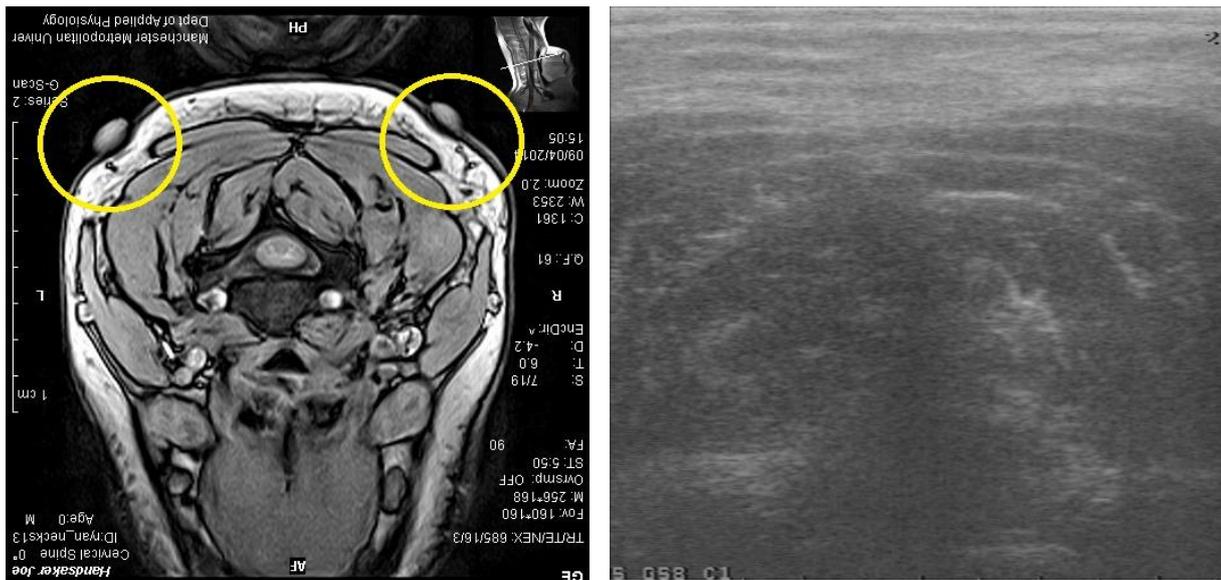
Left: MRI showing Cod liver oil capsules (within yellow circles). Right: associated ultrasound image.
